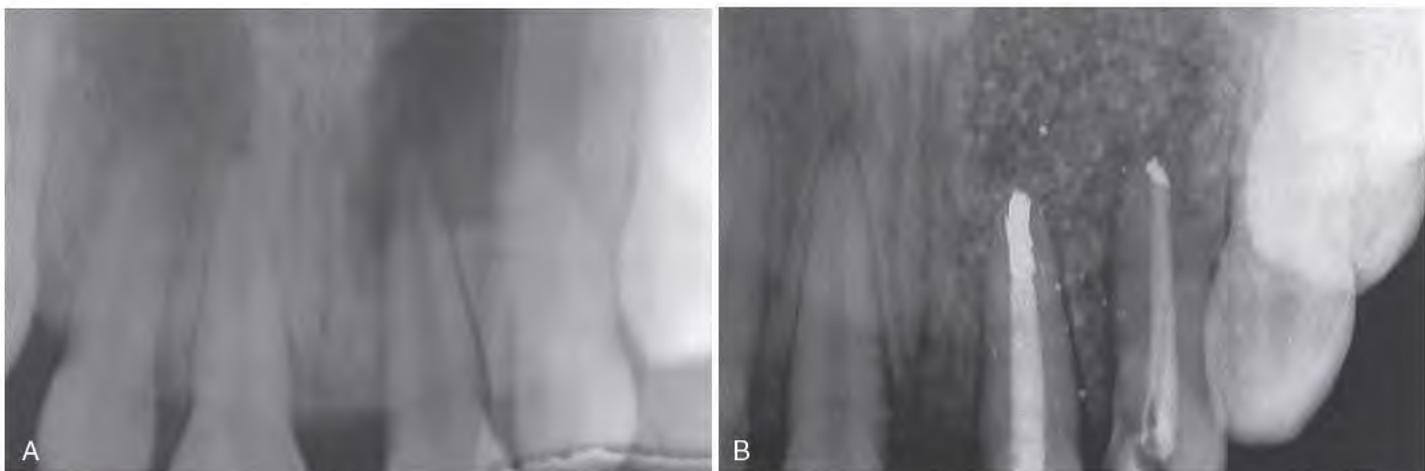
A and B, Cysts should not be repaired with graft material, because it prevents radiographic evidence of recurrence. However, grafting is acceptable if both facial and palatal cortical plates have been lost. These defects never fill in with bone; therefore they have a permanent radiolucency if not grafted.
